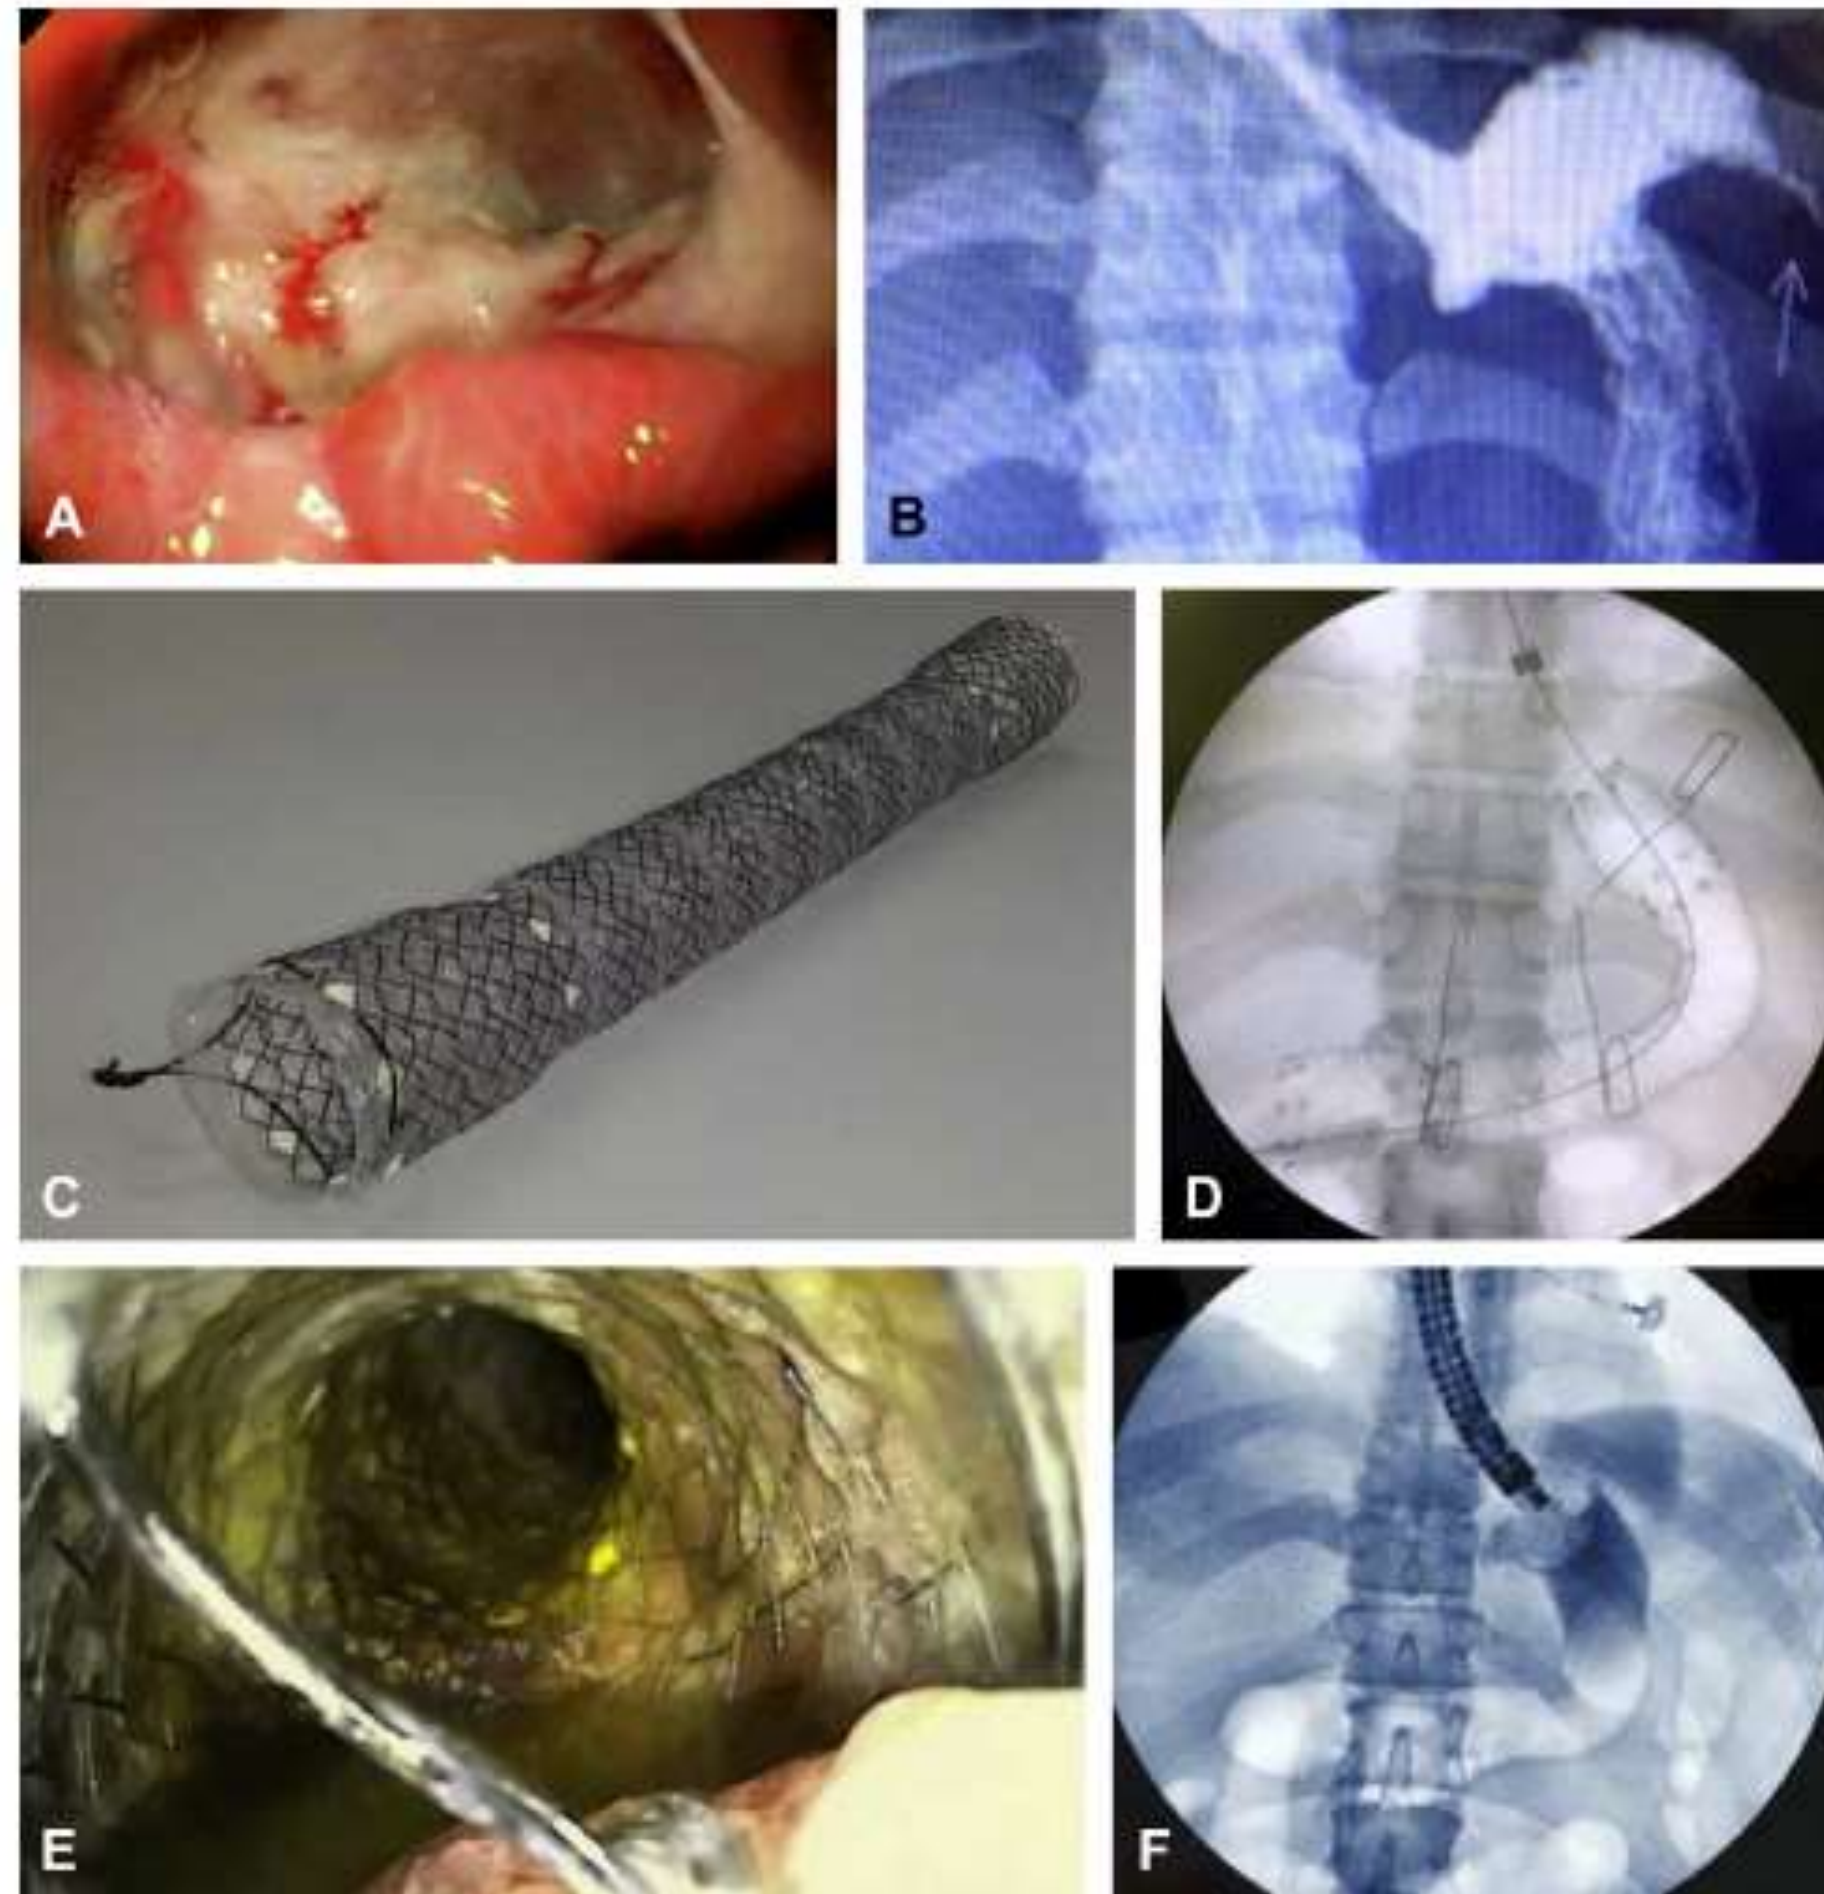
A, Endoscopic view of perigastric cavity and septum below the GEJ. B, Radiographic view of stomach with flow of contrast medium through leak orifice. C, Totally covered nitinol stent, 200 mm × 28 mm × 30 mm. D, Radioscopic control: stent positioned 3 cm above GEJ, in a transpyloric manner. E, Stent removal: proximal suture grasped by raptor forceps, with removal under radiologic control. F, Radiographic control after stent removal, showing resolution of axis deviation and closure of leak orifice. GEJ, gastroesophageal junction.
